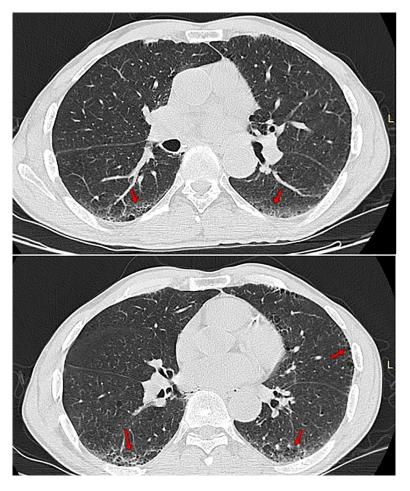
Initial RA-ILD lesions on the thoracic CT scan.
